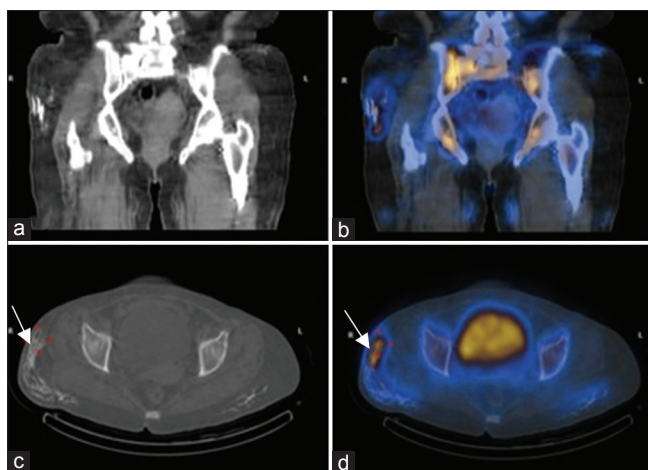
Single photon emission computed tomography/computed tomography (CT) (a) coronal CT, (b) coronal fused, (c) transaxial CT and (d) transaxial fused images of the pelvis and upper part of bilateral thighs showed tracer localization to extensive calcification exclusively in the subcutaneous fat of buttocks and anterior and lateral part of thigh (arrow on right sided involvement) on both sides
